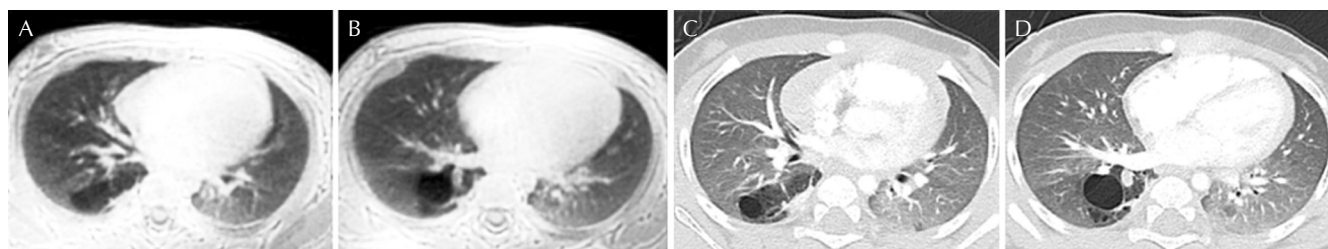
Multiple cystic lesions in a 6-month-old girl in the right lower lung, which was resected and pathologically diagnosed as bronchial atresia after resection. Pointwise encoding time reduction with radial acquisition (PETRA) (A and B) well demonstrates cystic lesions in the right lower lung compared with CT (C and D). The area of the cystic lesions is comparable between PETRA and CT. Small cystic lesions were better visualized on CT than on PETRA.
